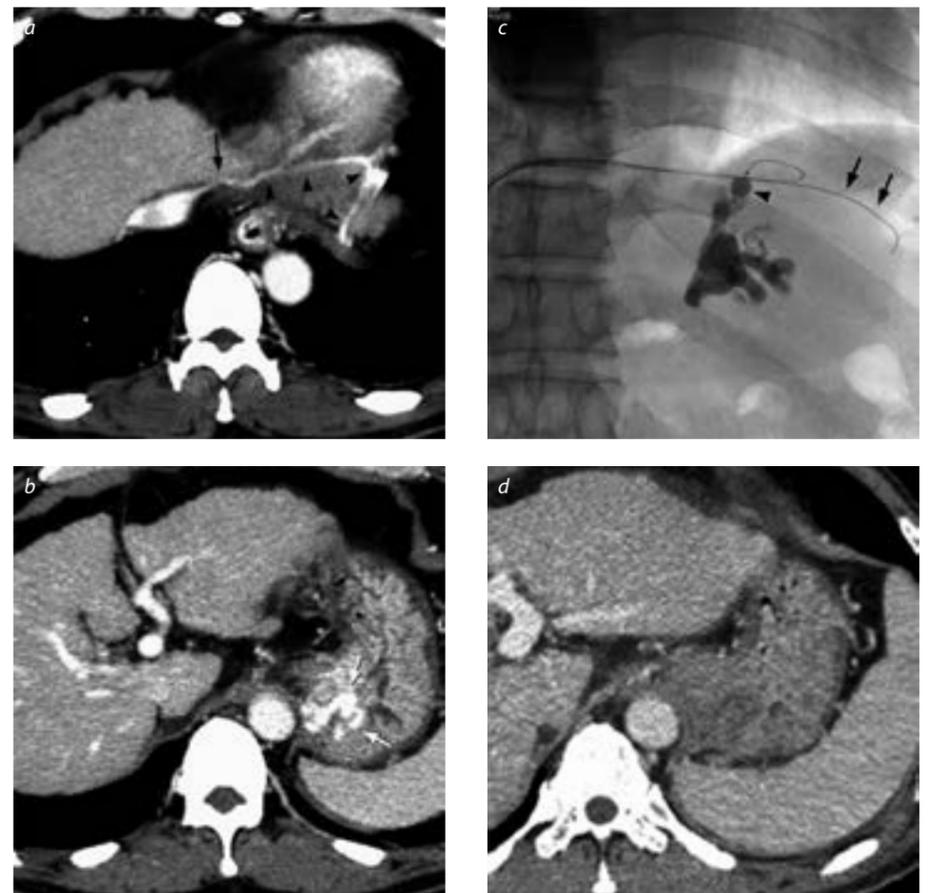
Gastric varices treated by BRTO technique. (a, b) Axial CT images show the gastric varices (white arrows) which drain through the left inferior phrenic vein (arrowheads) into the IVC. A stenotic portion of the left inferior phrenic vein (arrow) is also noted. (c) Fluoroscopic image during BRTO shows a microballoon catheter (arrow head) selectively advanced into the draining vein via the left inferior phrenic vein. Sclerosant (5% EOI) fills sufficiently in the varices. Arrows indicate a support guidewire inserted into the peripheral branch of the inferior phrenic vein. (d) Contrast-enhanced CT 1 week after BRTO shows complete obliteration of the varices.
